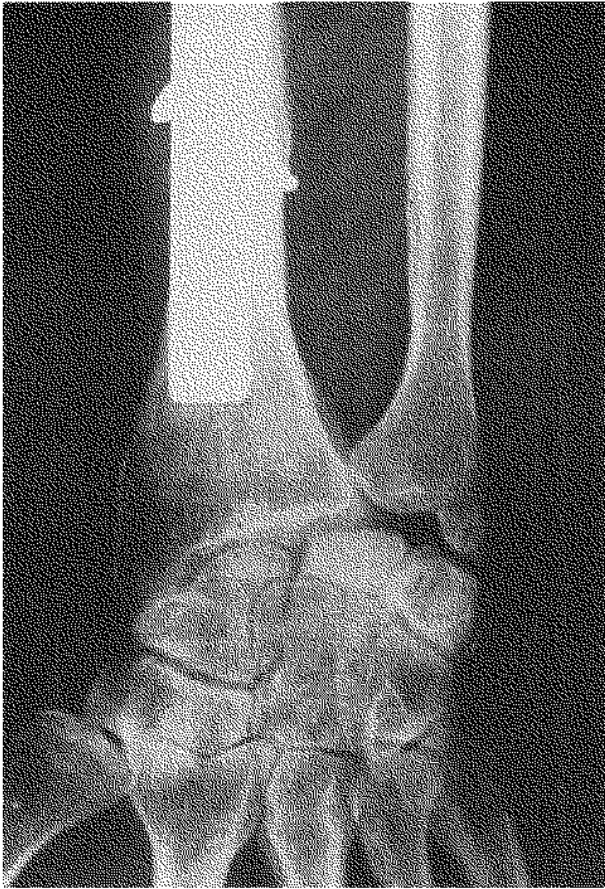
Case 1*: preoperative xray with degeneration of the DRUJ and silicone synovitis.
